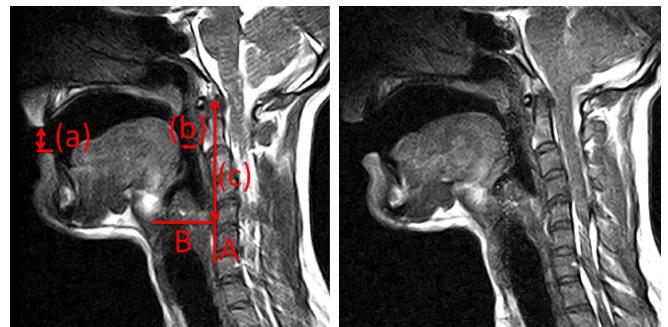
Modal A4 in upright (l) and supine (r) position. Auxiliary lines and distances measured in MR images: a=lip opening, b=oropharynx width, c=larynx position (see text).
